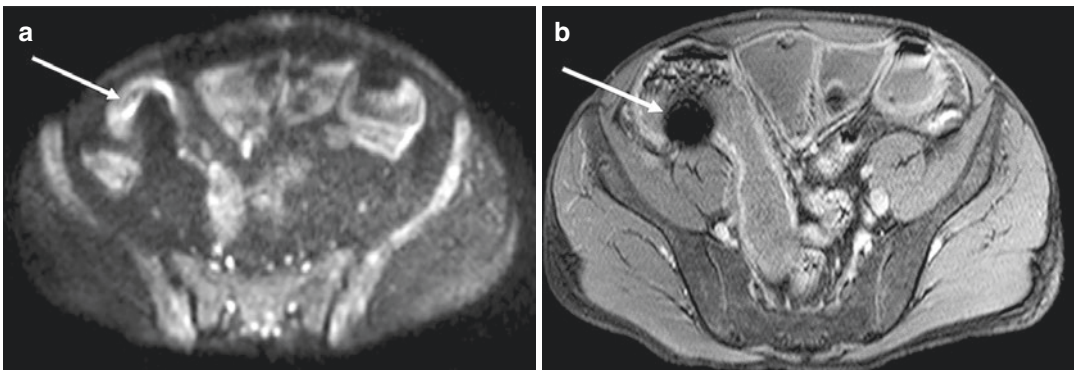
Axial DWI scan at 800 s/mm² (a) shows high-intensity signal at the level of the last ileal loop (arrow). The comparison with contrast-enhanced axial GE T1-w
